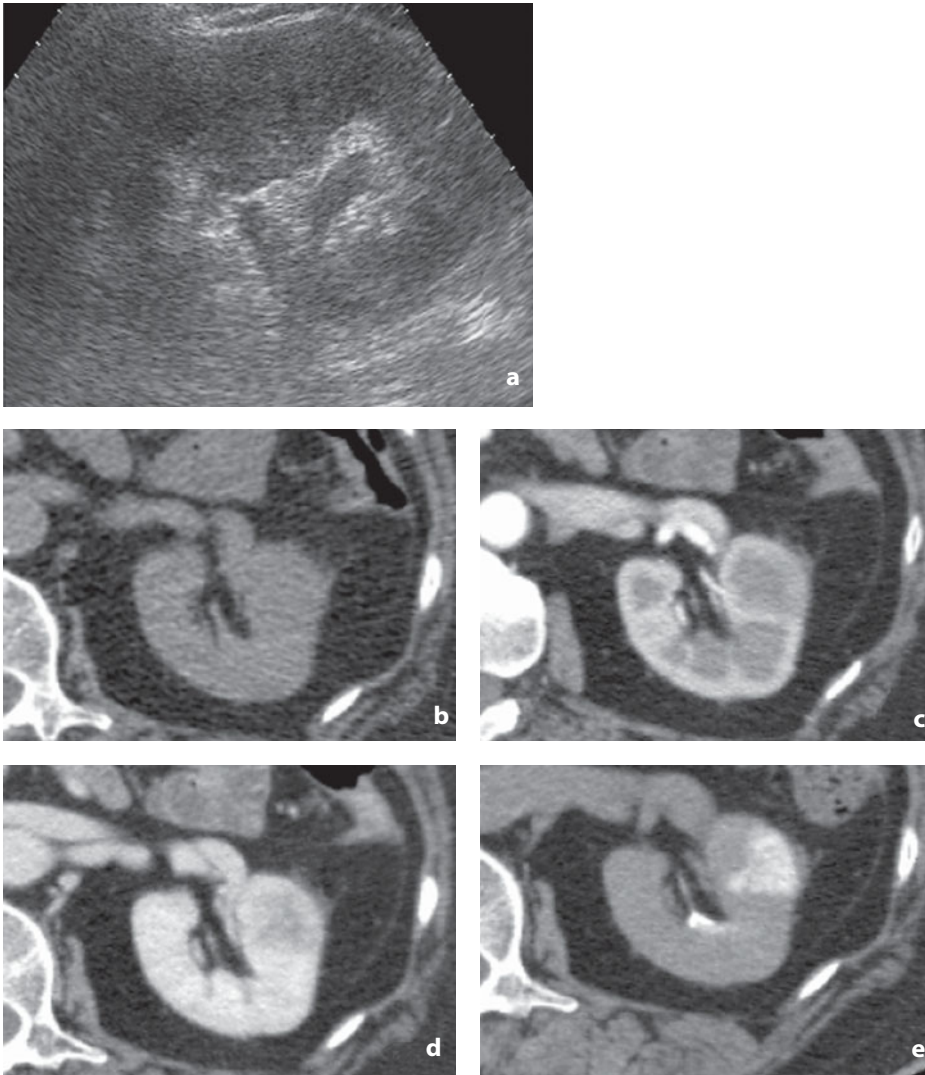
Ultrasonography and contrast-enhanced CT. Acute focal pyelonephritis. a The US study shows moderate bulging of the renal profile corresponding to a hypoechoic area with ill-defined margins. b The non-enhanced CT image shows slight hypoattenuating swelling with ill-defined margins and perirenal fat stranding. c,d After contrast medium injection the presence of a hypoattenuating area is poorly defined in the cortical phase (c) but clear in the parenchymal phase (d). e In the delayed phase, 3 h after contrast medium injection, the formerly hypoattenuating area is now clearly hyperattenuating due to delayed nephrogram resulting from tissue edema and tubular obstruction
